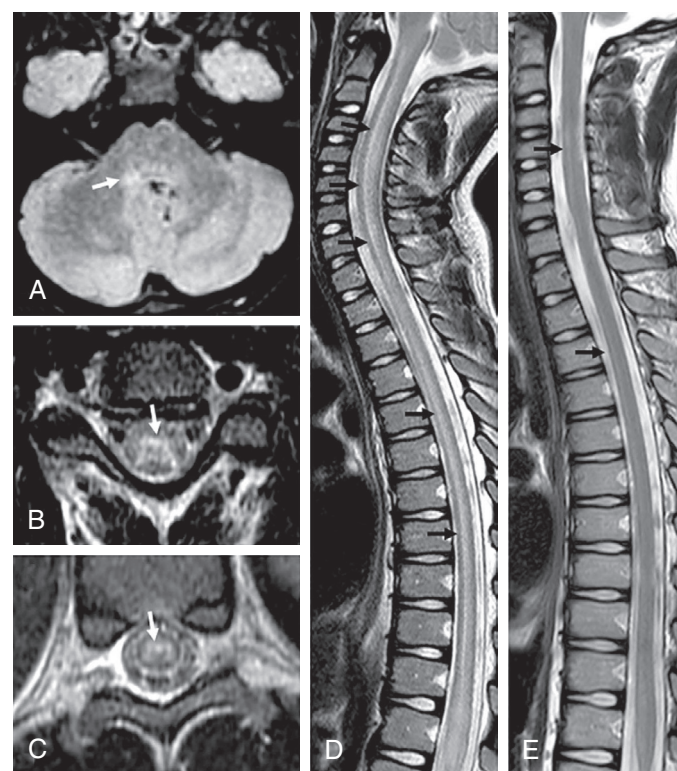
■ Representative brain and spinal cord MR images in setting of EV-D68 infection with flaccid paralysis and cranial nerve dysfunction. Taken in the acute phase of illness, axial images A, B, and C show T2 hyperintensity in the right dorsal pons (white arrow, Panel A) and central hyperintensity in the central gray matter (white arrows, Panels B and C). Sagittal cord images show a progression from an extensive, ill-defined T2 hyperintensity in the acute phase of illness (black arrows, Panel D) to a signal hyperintensity that coalesces around the anterior horn cells 38 days into illness (black arrows, Panel E). (Modified from Maloney JA, Mirsky DM, Messacar K, et al. MRI findings in children with acute flaccid paralysis and cranial nerve dysfunction occurring during the 2014 enterovirus D68 outbreak. *Am J Neuroradiol* 2015;36:245–250; Fig. 4.)
